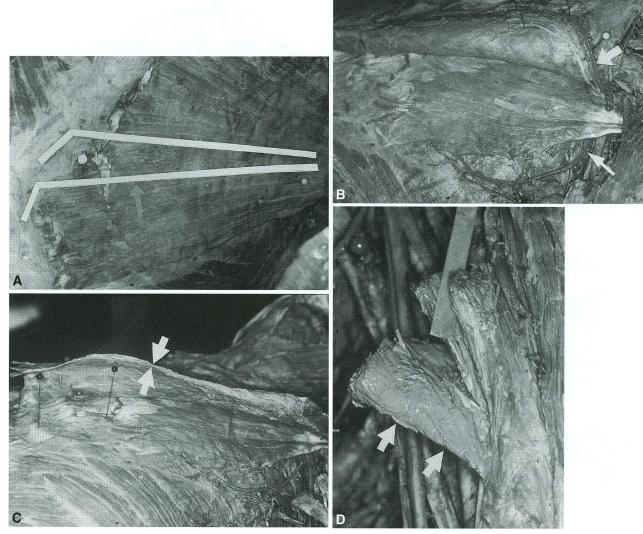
Anatomic study showing (A) where the fourth *perforans* of the thoracic artery is based in relation to the parasternal border (*white dot*). The muscle incisions used to shape the flaps can be carried out on the superior or inferior limits related to the projection of this *perforans*. (B) The pectoral artery, a branch of the thoracoacromial artery, slides over the deep surface of the *pectoralis major* muscle, penetrates the muscle, and is anastomosed with the *perforans* branches of the internal thoracic artery (*large arrow*). The lateral thoracic artery circles
